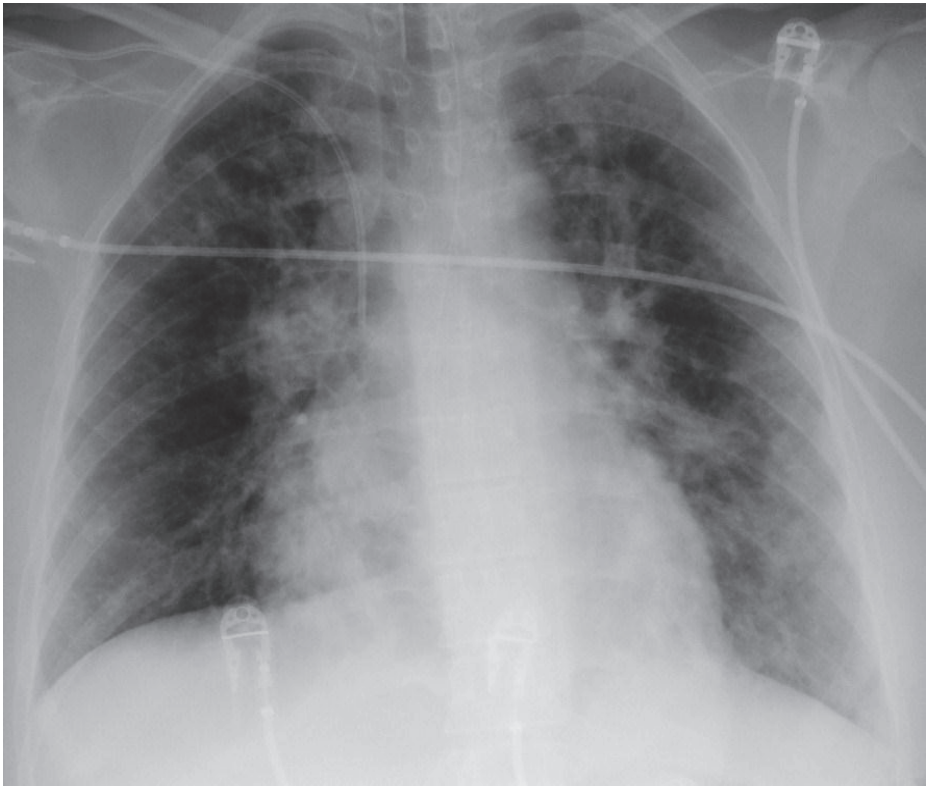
A typical chest radiograph finding of a SCAP patient with bronchopneumonia showing bilateral diffuse opacities in all lung lobes.
